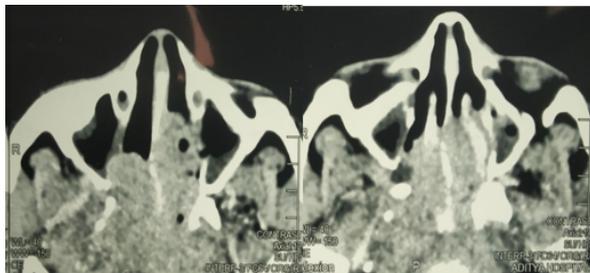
CT Nasopharynx and Paranasal sinus images of the patient
